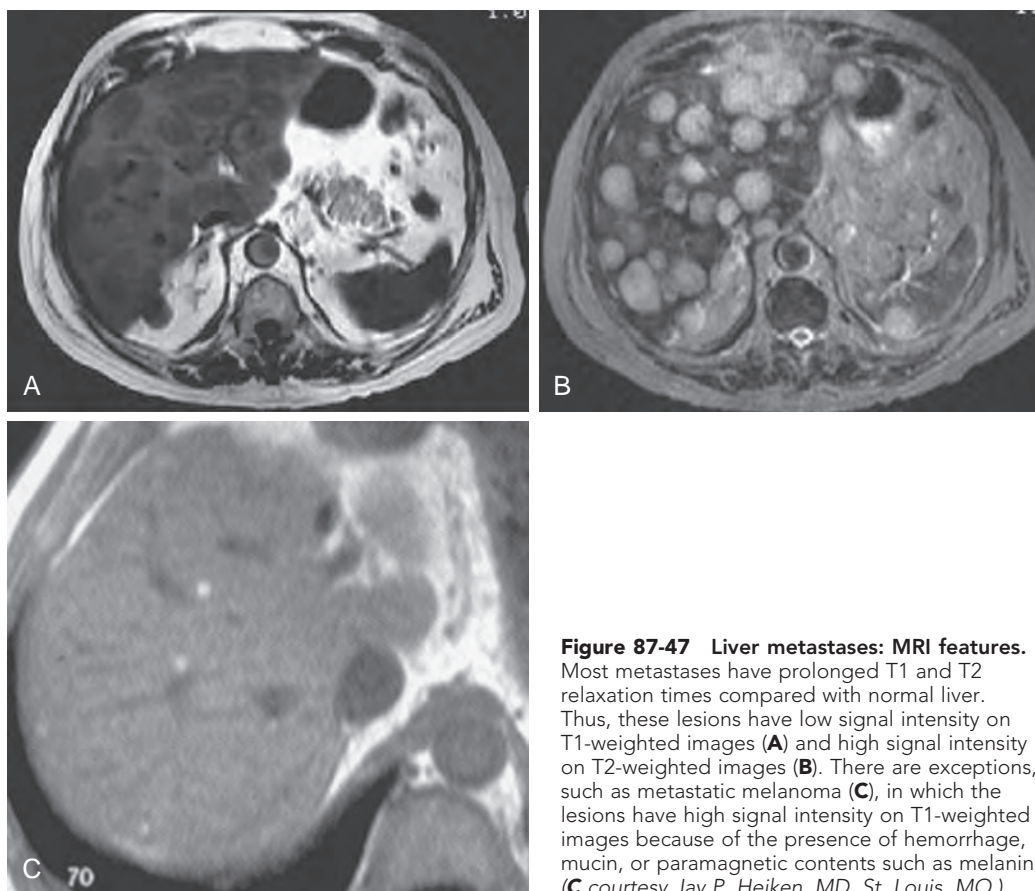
Liver metastases: MRI features.
